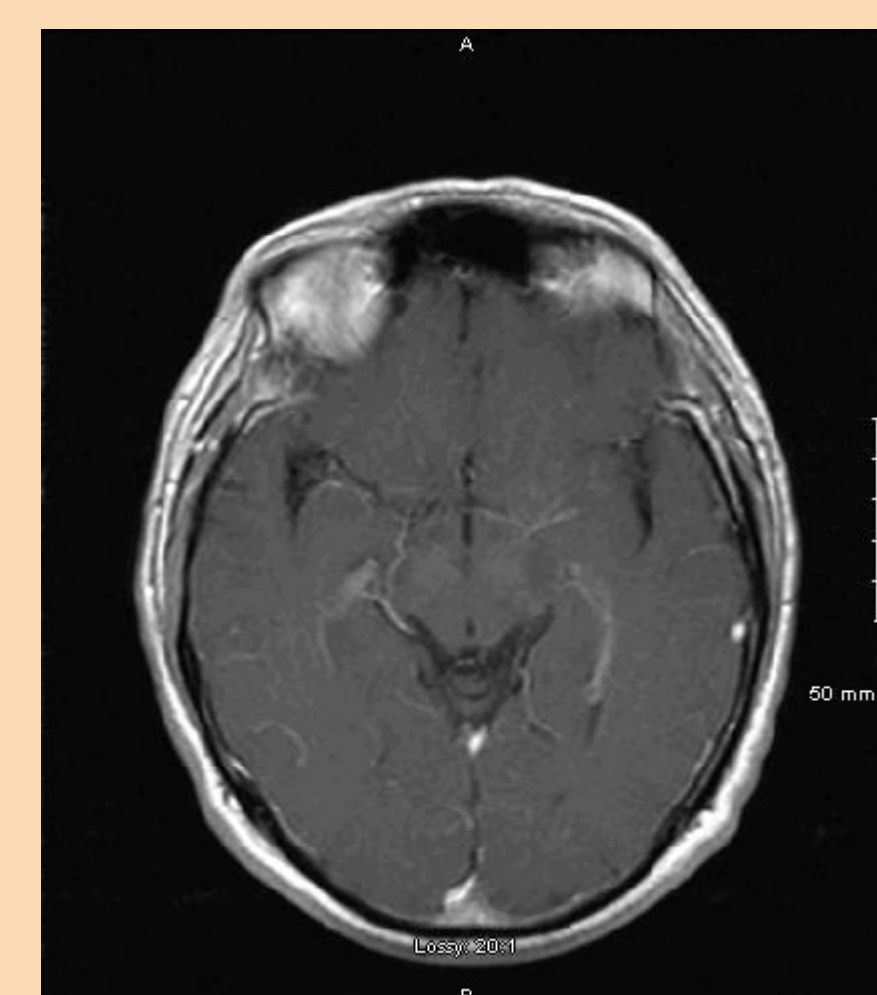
MRI T1 Axial + GAD showing resolution of lesion to left geniculate body. 8/2016
